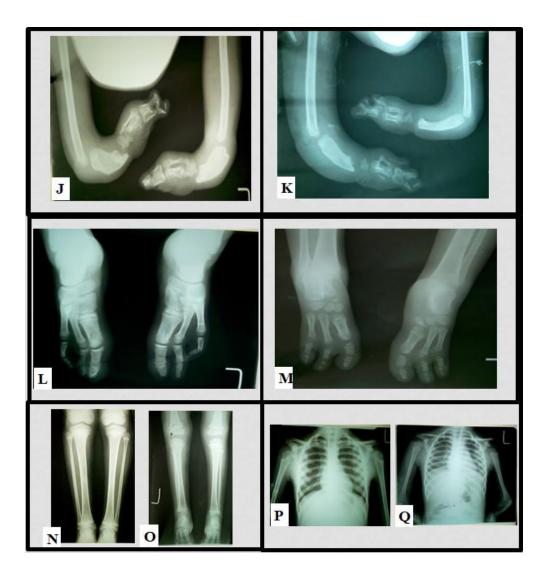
Representation of internal anatomical structures of thoracic and appendicular skeleton through radiographs of affected individuals 502 (J,L,N,O) and 505 (K,M,P,Q)
